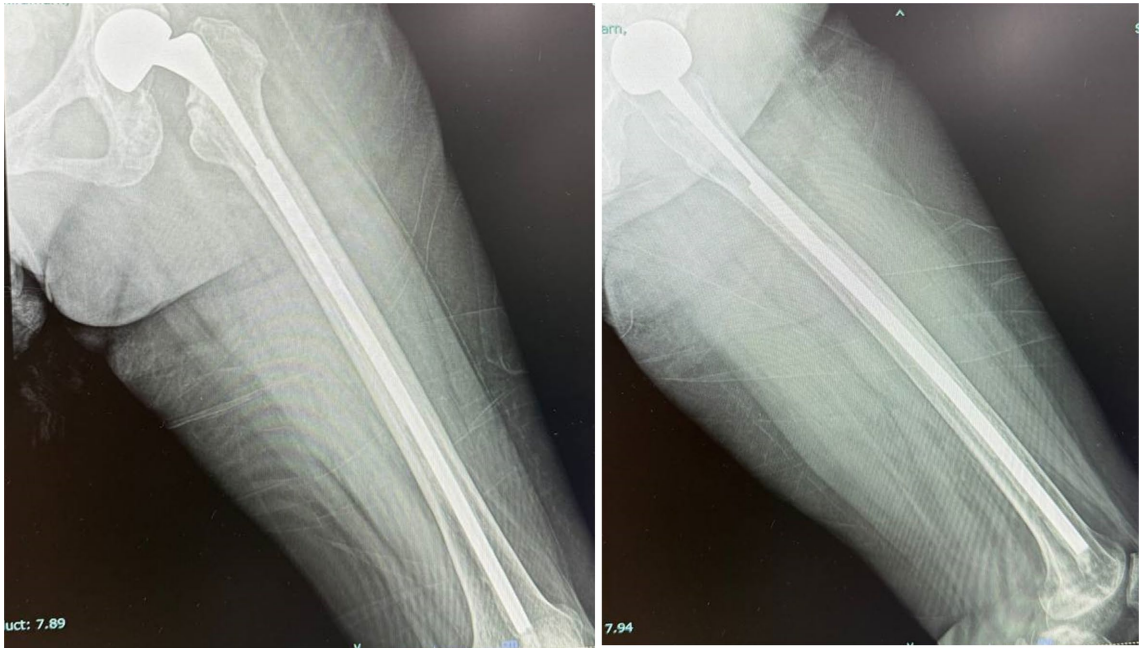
Post-operative X-rays films showing good implant length obtained with the technique.
